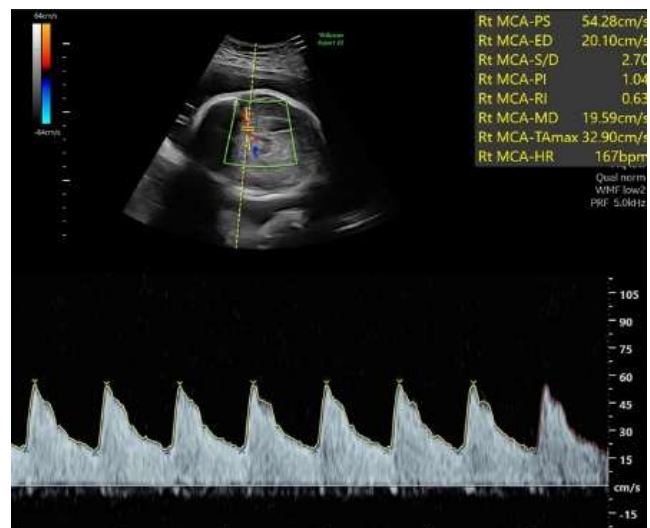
Middle cerebral artery Doppler for twin 1.
